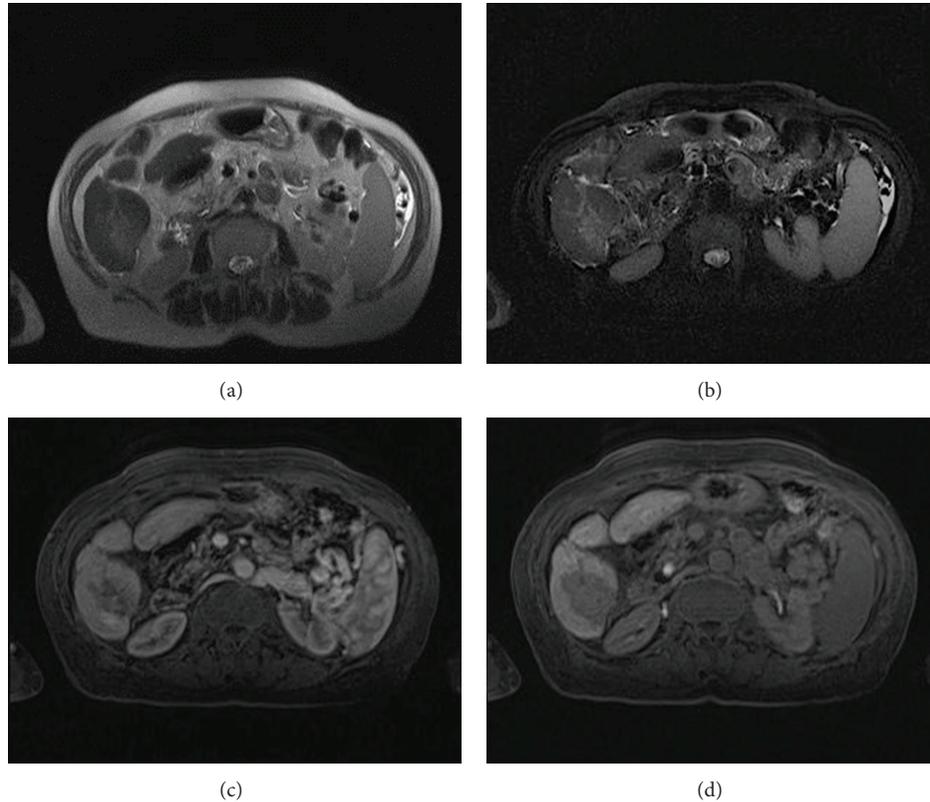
50-year-old man with an ablated HCC at segment 6. At three months, MRI showed that at T2-W (a) and T2-W FS (b) there was no inflammatory reactions while during arterial (c) and hepatospecific phase (d) residual disease was evident.
